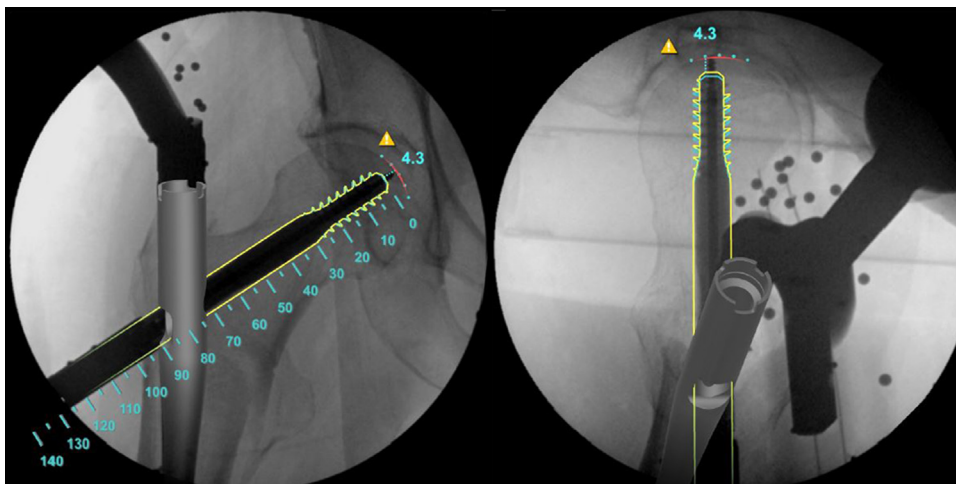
Images from the ADAPT navigation system. The software superimposes the nail and screw on the live radiographs and is then able to calculate a tip-to-apex distance to help the surgeon with screw placement. The system allows for tracking of screw placement in real-time.
